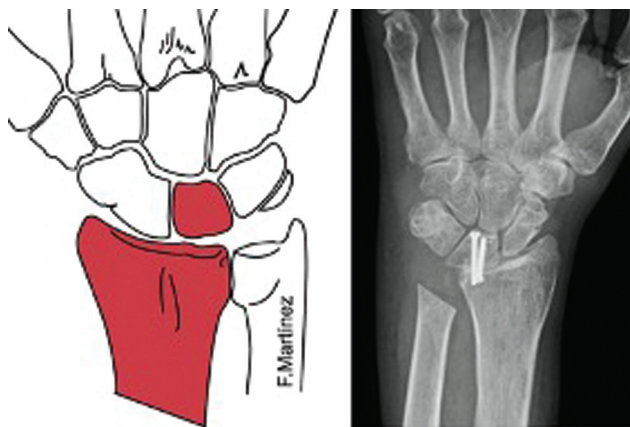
Radioscapholunate arthrodesis. The computed tomography (CT) scan shows volar subluxation of the carpus after distal radius fracture with a volar marginal fragment. On the right, RSL arthrodesis is observed after plate removal; note the distal pole resection of the scaphoid.
